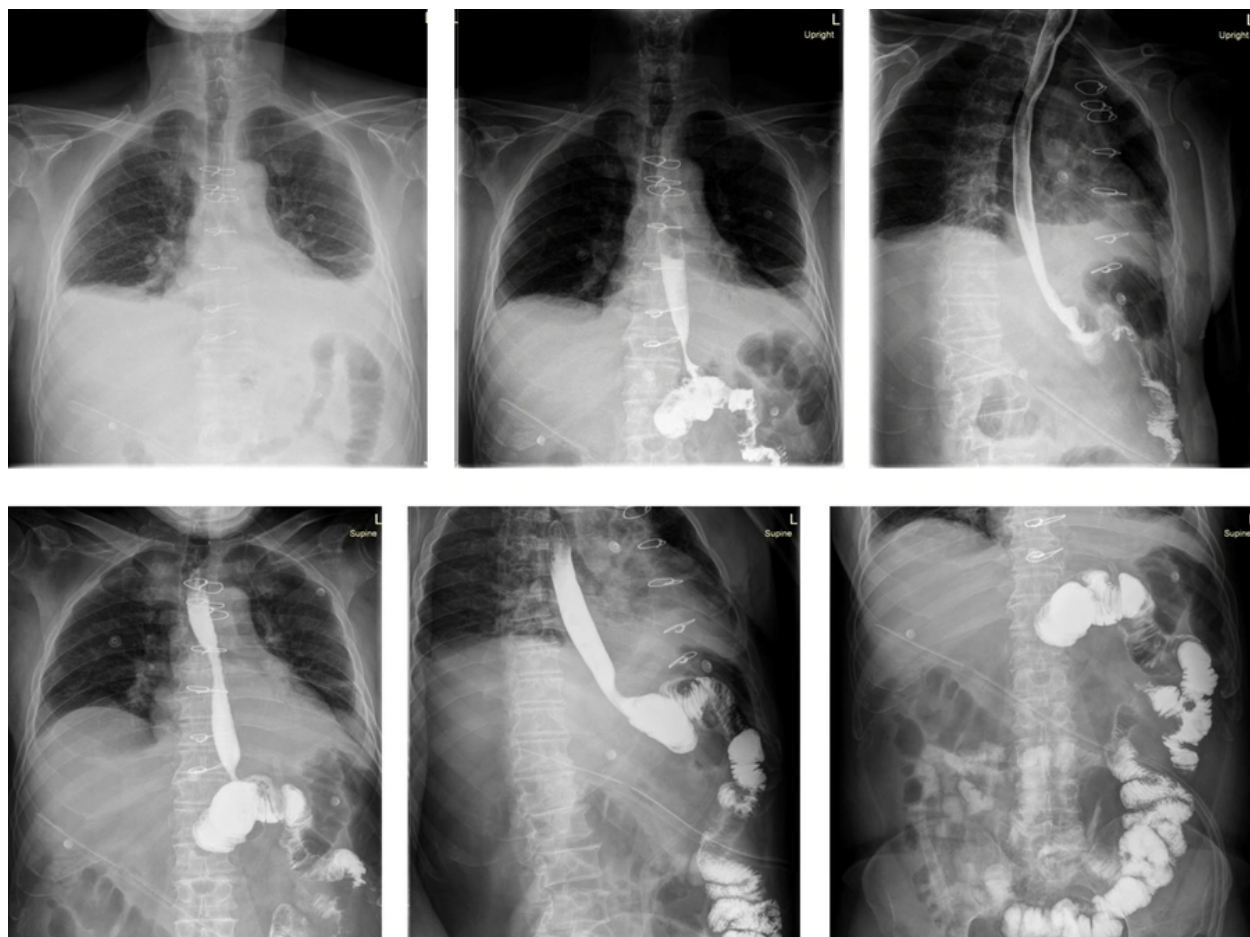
A 56-year-old man after total gastrectomy and partial esophagostomy, with an elevated C-reactive protein (CRP) level of 58 mg/L but no evidence of anastomotic leakage on radiographic evaluation
